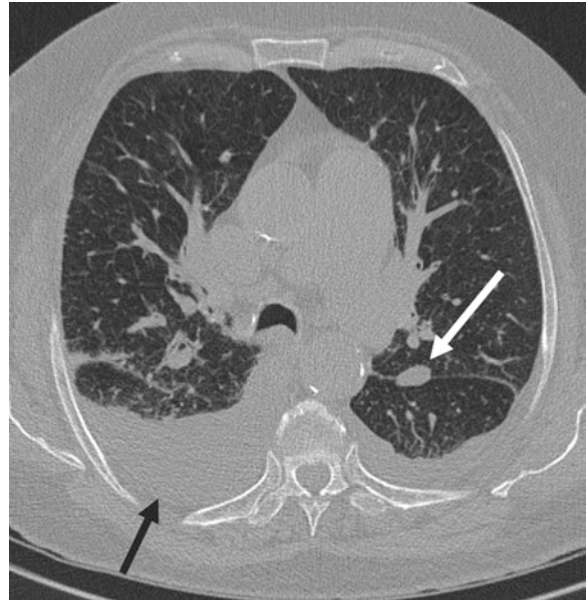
Axial chest CT from a COVID-19 patient. There is a right-sided moderate pleural effusion (black arrow) and left-sided intra-fissure lymphadenopathy (white arrow). Pleural effusion and lymphadenopathy are not common in COVID-19 infection
